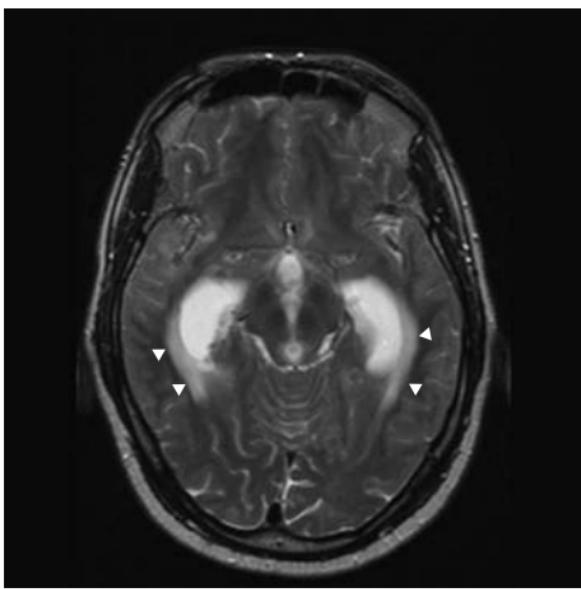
Parenchymal TB. Axial (a) post-contrast-enhanced and (b) T2-weighted MRI. Multiple ring enhancing nodules in infra- and supratentorial compartments with surrounding white matter vasogenic oedema. Note meningeal involvement with obstructive hydrocephalus and periventricular transependymal interstitial oedema lateral to the grossly dilated temporal horns ((b) white arrowheads).
